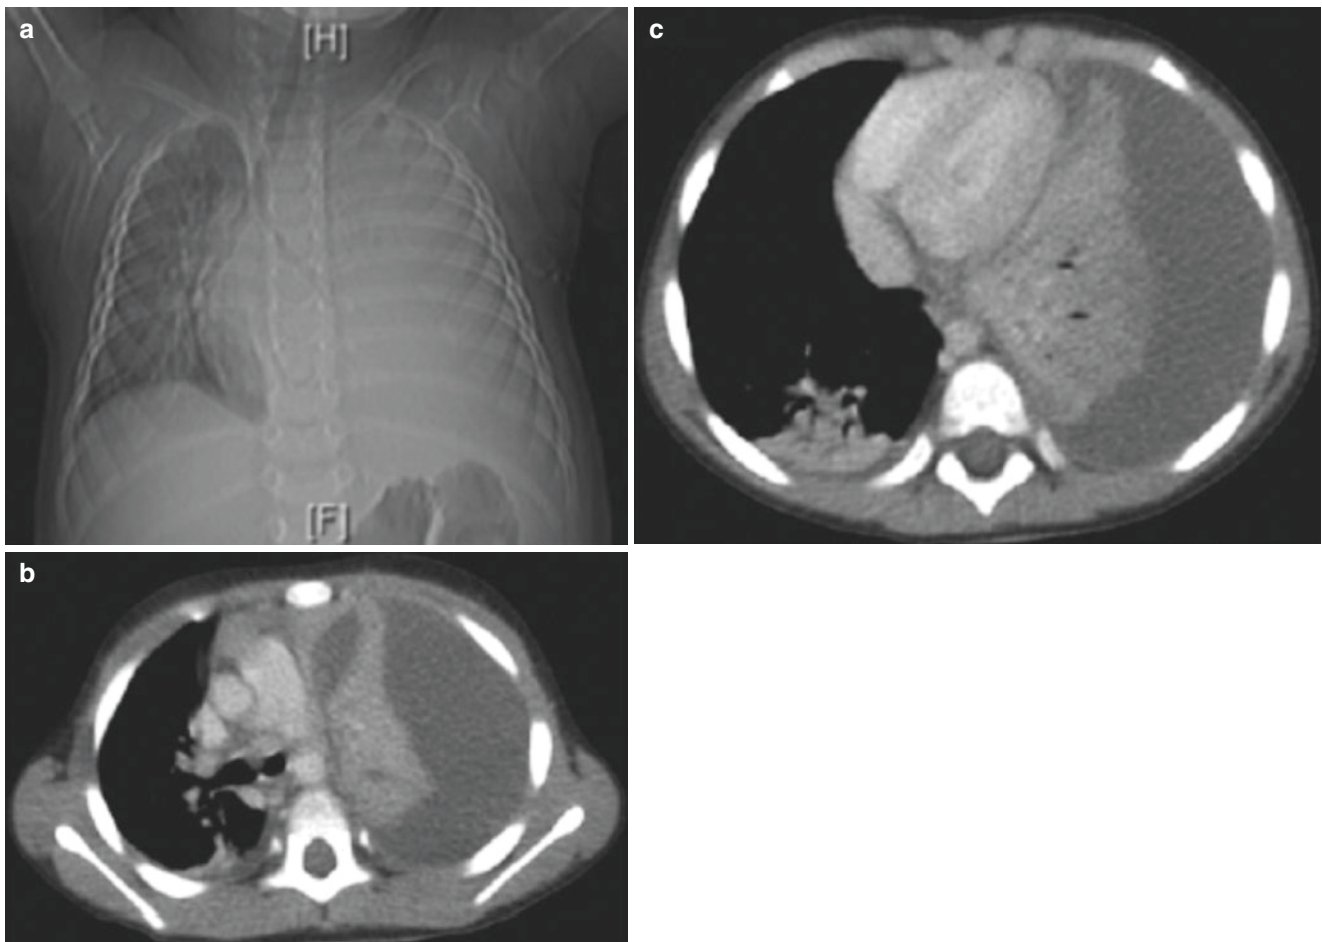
Frontal chest radiograph (a) and CT images (b, c) demonstrate a large left pleural effusion with substantial deviation of the mediastinum to the right
